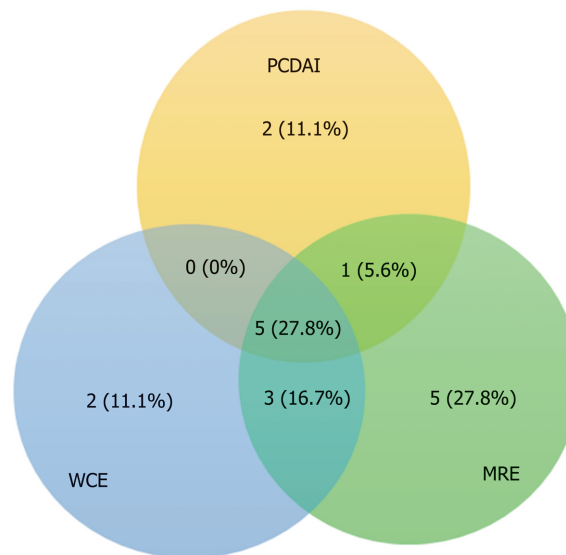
Concordance rate of positive small bowel involvement in the pediatric Crohn's disease activity index, positive magnetic resonance imaging, and wireless capsule endoscopy modalities in all patients $n = 26$. PCDAI: Pediatric Crohn's disease Activity Index; MRE: Magnetic resonance enterography; WCE: Wireless capsule endoscopy.
